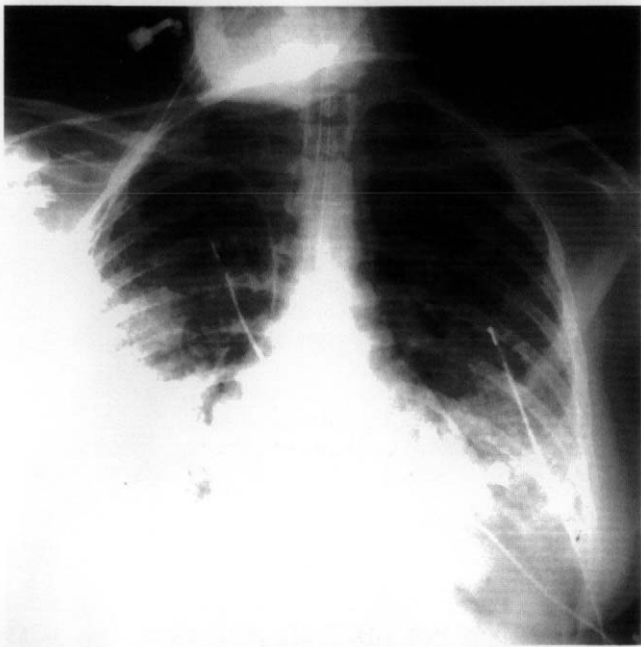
Chest radiograph following intubation showing diffuse infiltrates.
